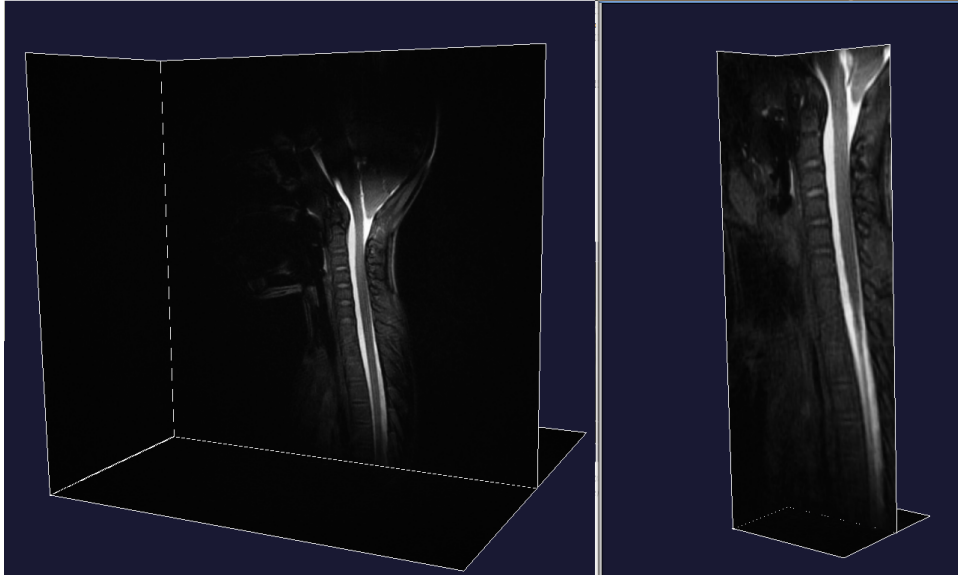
MRI-scan of a person with the Chiari Malformation (left) and the extracted volume of interest which we use for model creation(right).*
